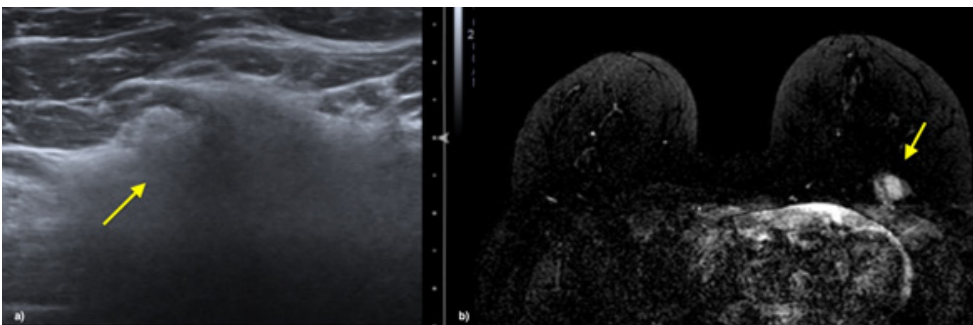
A complementary ultrasound study (a), which demonstrated the presence of the “snowstorm” signal was performed, and the MRI (b) study revealed the presence of hypersignal in the selective sequence for the silicone. These findings are compatible with free silicone, these characteristics being described later in this article.
